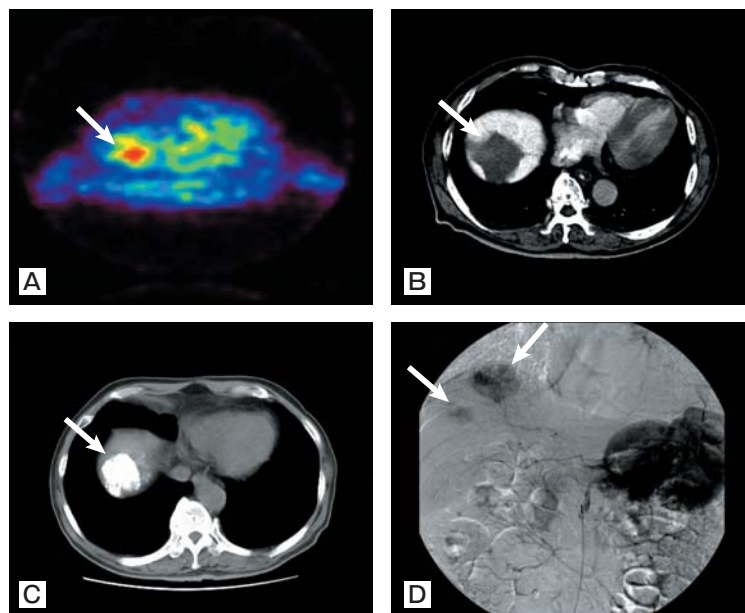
Abdominal CT and angiography revealed the liver tumors to be located in the right upper lobe, which was thus compatible with HCC. A, FDG-PET showed a strong accumulation in the liver tumor. The standardized uptake value (SUV) of FDG was 3.42. B, CT angiography; C, CT hepatic angiography, early phase; D, digital subtraction angiography.
